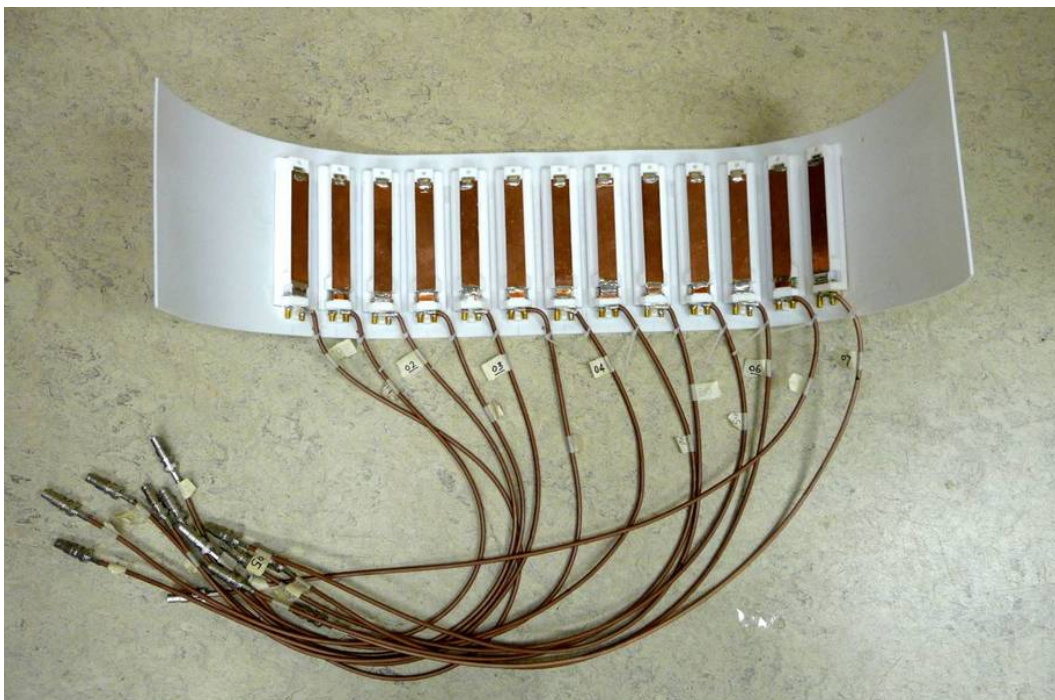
A 7-channel ^{31}P /6-channel ^1H external chest coil for non-invasive cardiac MRI/MRS study at 9.4 Tesla.
